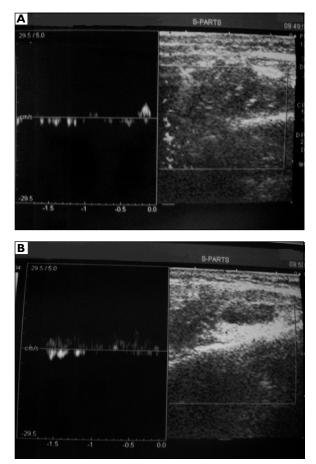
Colour Doppler sonography of the right masseter muscle showing slow-flow venous Doppler signals. B. Colour Doppler sonography of the right masseter muscle showing some arterialized flow with low resistance
